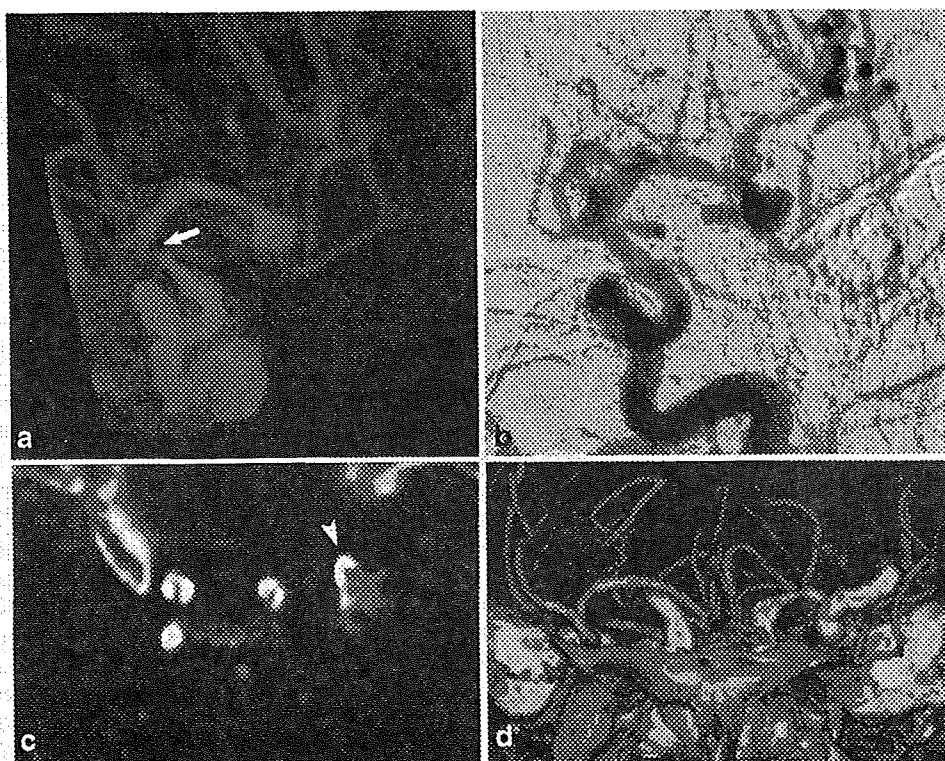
Left MCA calcified aneurysm and bilateral ICA stenosis with hard plaque in a 77-year-old female patient. MIP image of DE-BR-CTA (a) removed the calcifications of ICA and aneurysm and revealed the same aneurysm shape as with DSA (b). However, the DE-BR-CTA (a) shows a short defect at the severe stenotic site at ICA terminal (arrow). CTA source images (c) show dense calcifications around the whole circumference of the ICA and anterior wall of the left MCA aneurysm (arrowheads). VR image of conventional CTA (d) showed the dense calcification at bilateral ICA and aneurysms, but failed to reveal details
